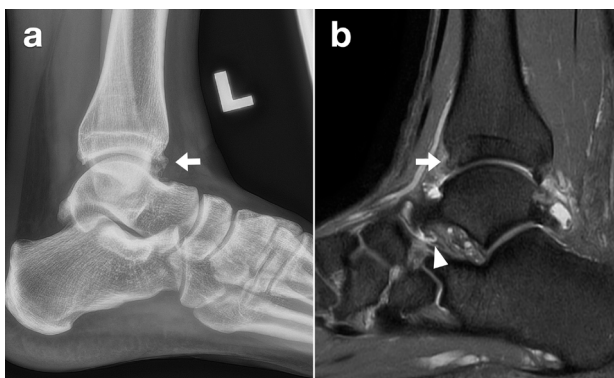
Ankle radiograph in lateral view (a) showed anterior distal tibia marginal osteophyte (arrow). MRI ankle PDFS sequence in sagittal view (b) showed the osteophyte (arrow) and fluid in the anterior sinus tarsi (arrowhead) with diffuse soft tissue oedema.
